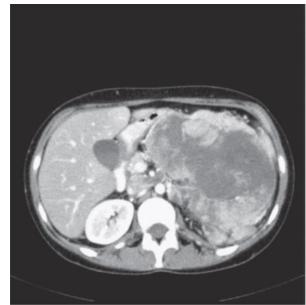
Axial CT scan obtained after intravenous contrast administration in a 16 - year - old girl with metastatic adrenocortical carcinoma. The scan demonstrates a large, heterogeneous retroperitoneal mass, measuring $15 \times 10 \times 18$ cm, with areas of necrosis. The mass is displacing adjacent organs. (5)
